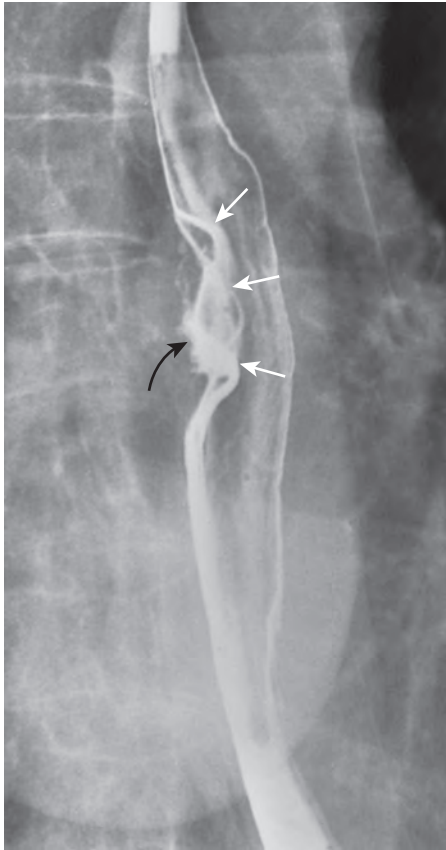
Small cell carcinoma of the esophagus. There is a smoothly margined, sessile mass (white arrows) containing a relatively flat central area of ulceration (black arrow) on the right posterolateral wall of the midesophagus below the level of the carina. Squamous cell carcinoma of the esophagus could produce identical findings. (From Levine MS, Pantongrag-Brown L, Buck JL, et al: *Small cell carcinoma of the esophagus: Radiographic findings*. Radiology 199:703–705, 1996.)
